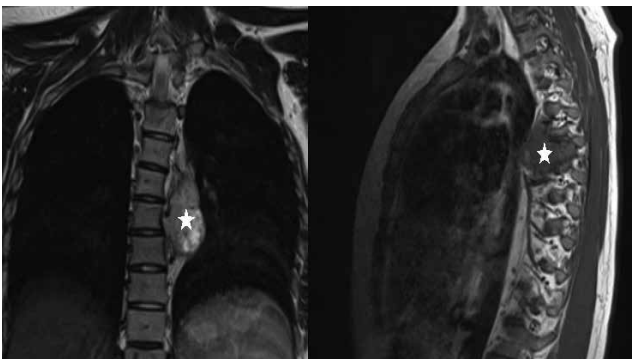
Magnetic resonance imaging revealed that the paravertebral mass was located between the descending aorta and T4-T7 vertebrae without vertebral destruction.
